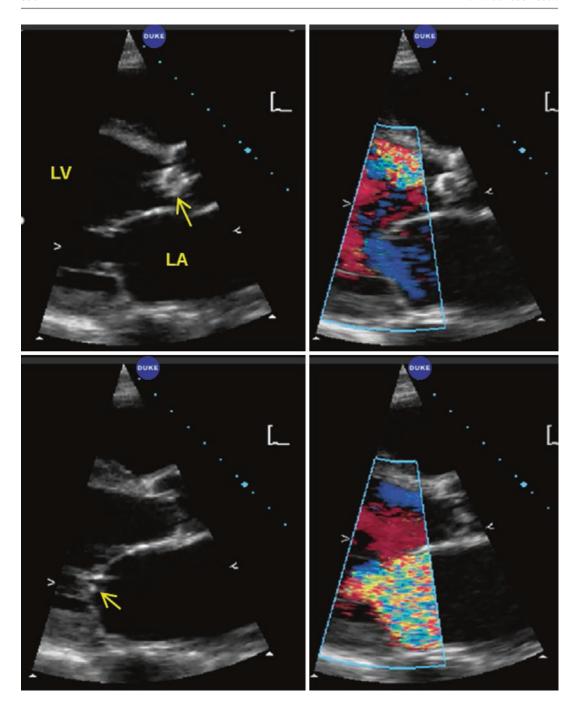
Paired parasternal long axes in diastole (top row) and systole (bottom row) in a patient with a large mass lesion on the aortic valve (arrow top left) and a tiny
